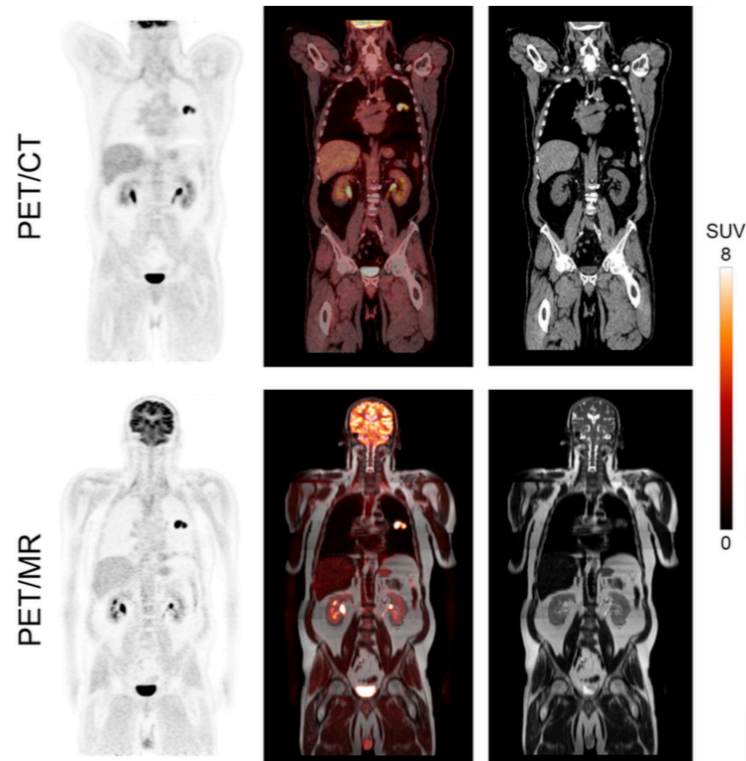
PET/CT vs PET/MR images from a same patient<sup>4</sup>
